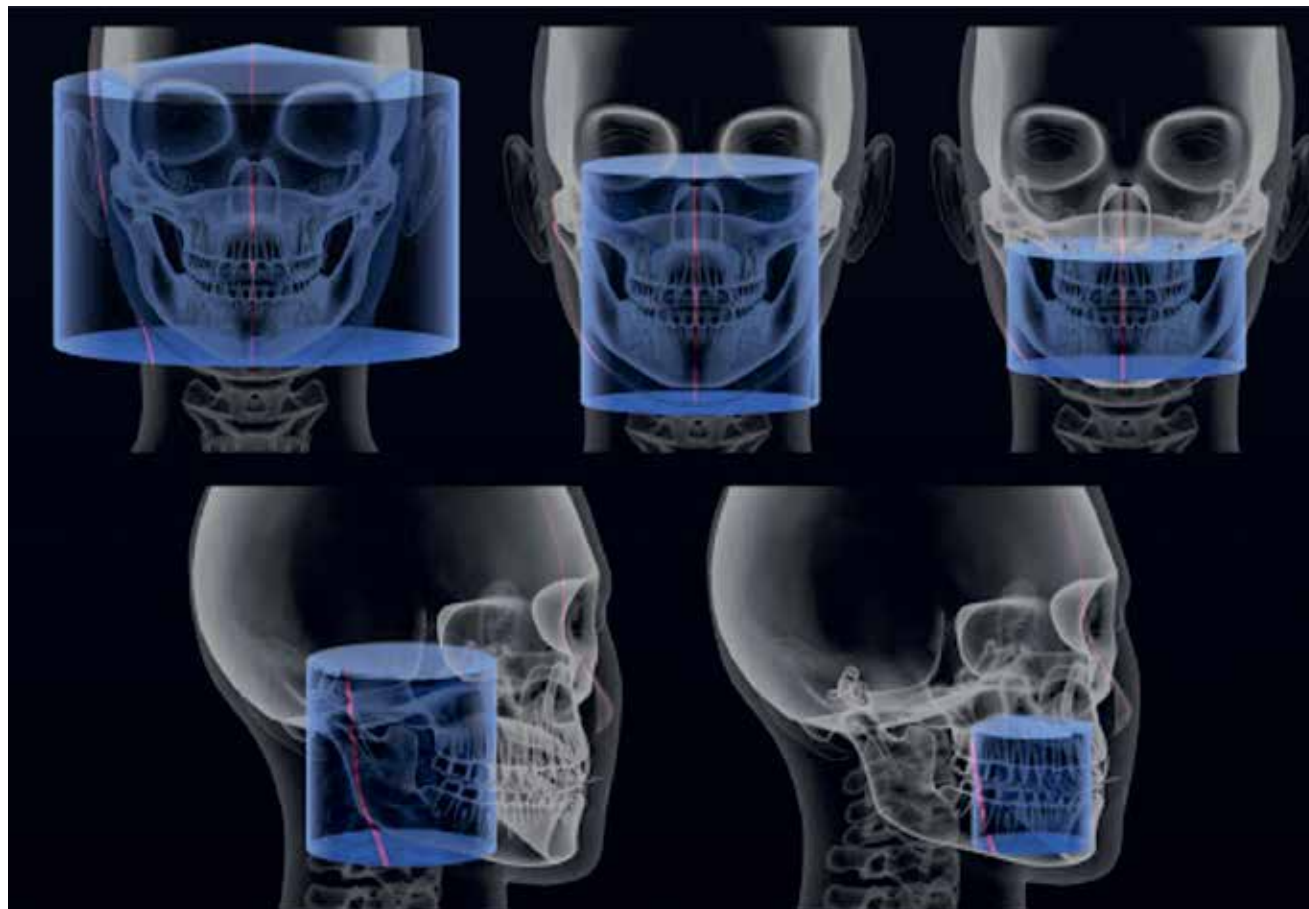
There are a variety of available FOVs in modern CBCT machines; these range from very small (40 × 40 mm) to very large to include almost the entire head of the patient (230 × 230 mm).
